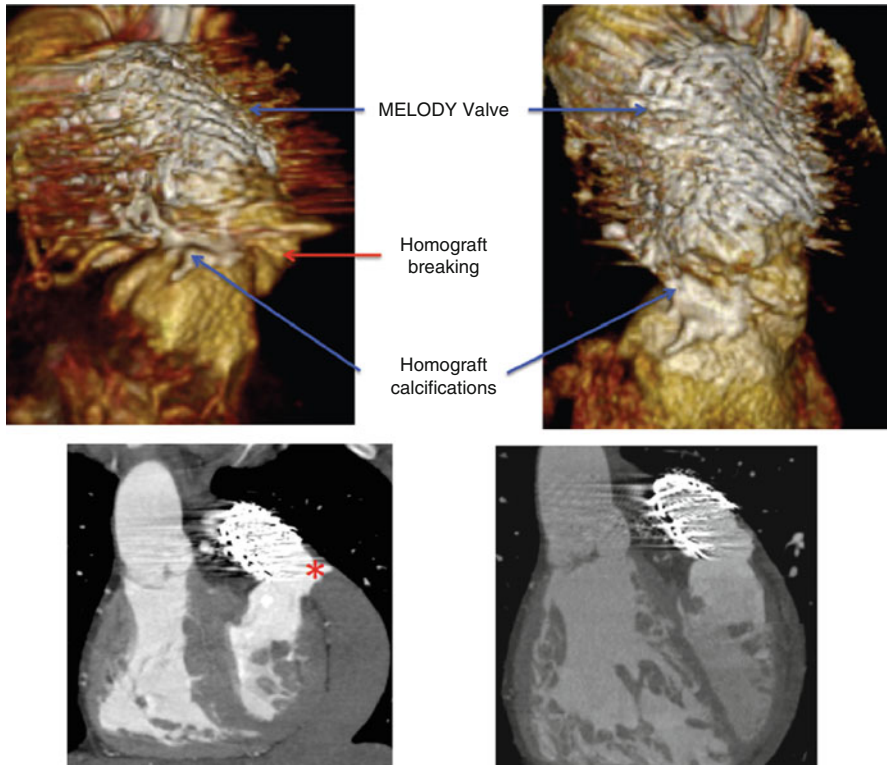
3D reconstruction CT image (*up*) and CT scan of the right ventricular outflow in a patient following transcatheter valvulation with a 22 mm Melody Valve showing a tear with extravasation that is confined (*). A moderate pericardial effusion resolved over 5 days. No further intervention was required. Ultimately the result of transpulmonary valvulation was satisfactory
